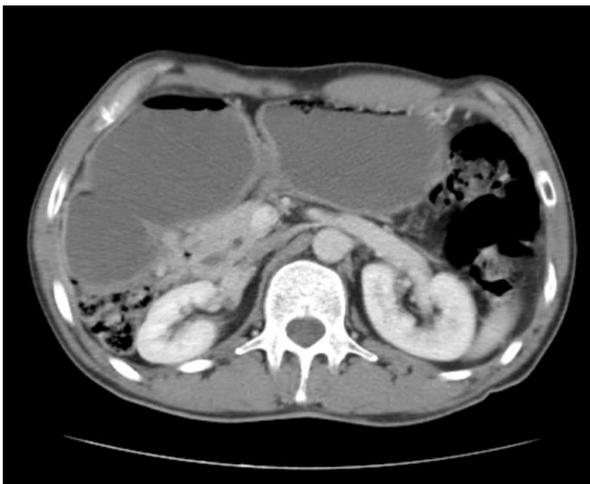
Abdominal CT showing an extrinsic duodenal stenosis upstream of an annular aspect of the pancreas
